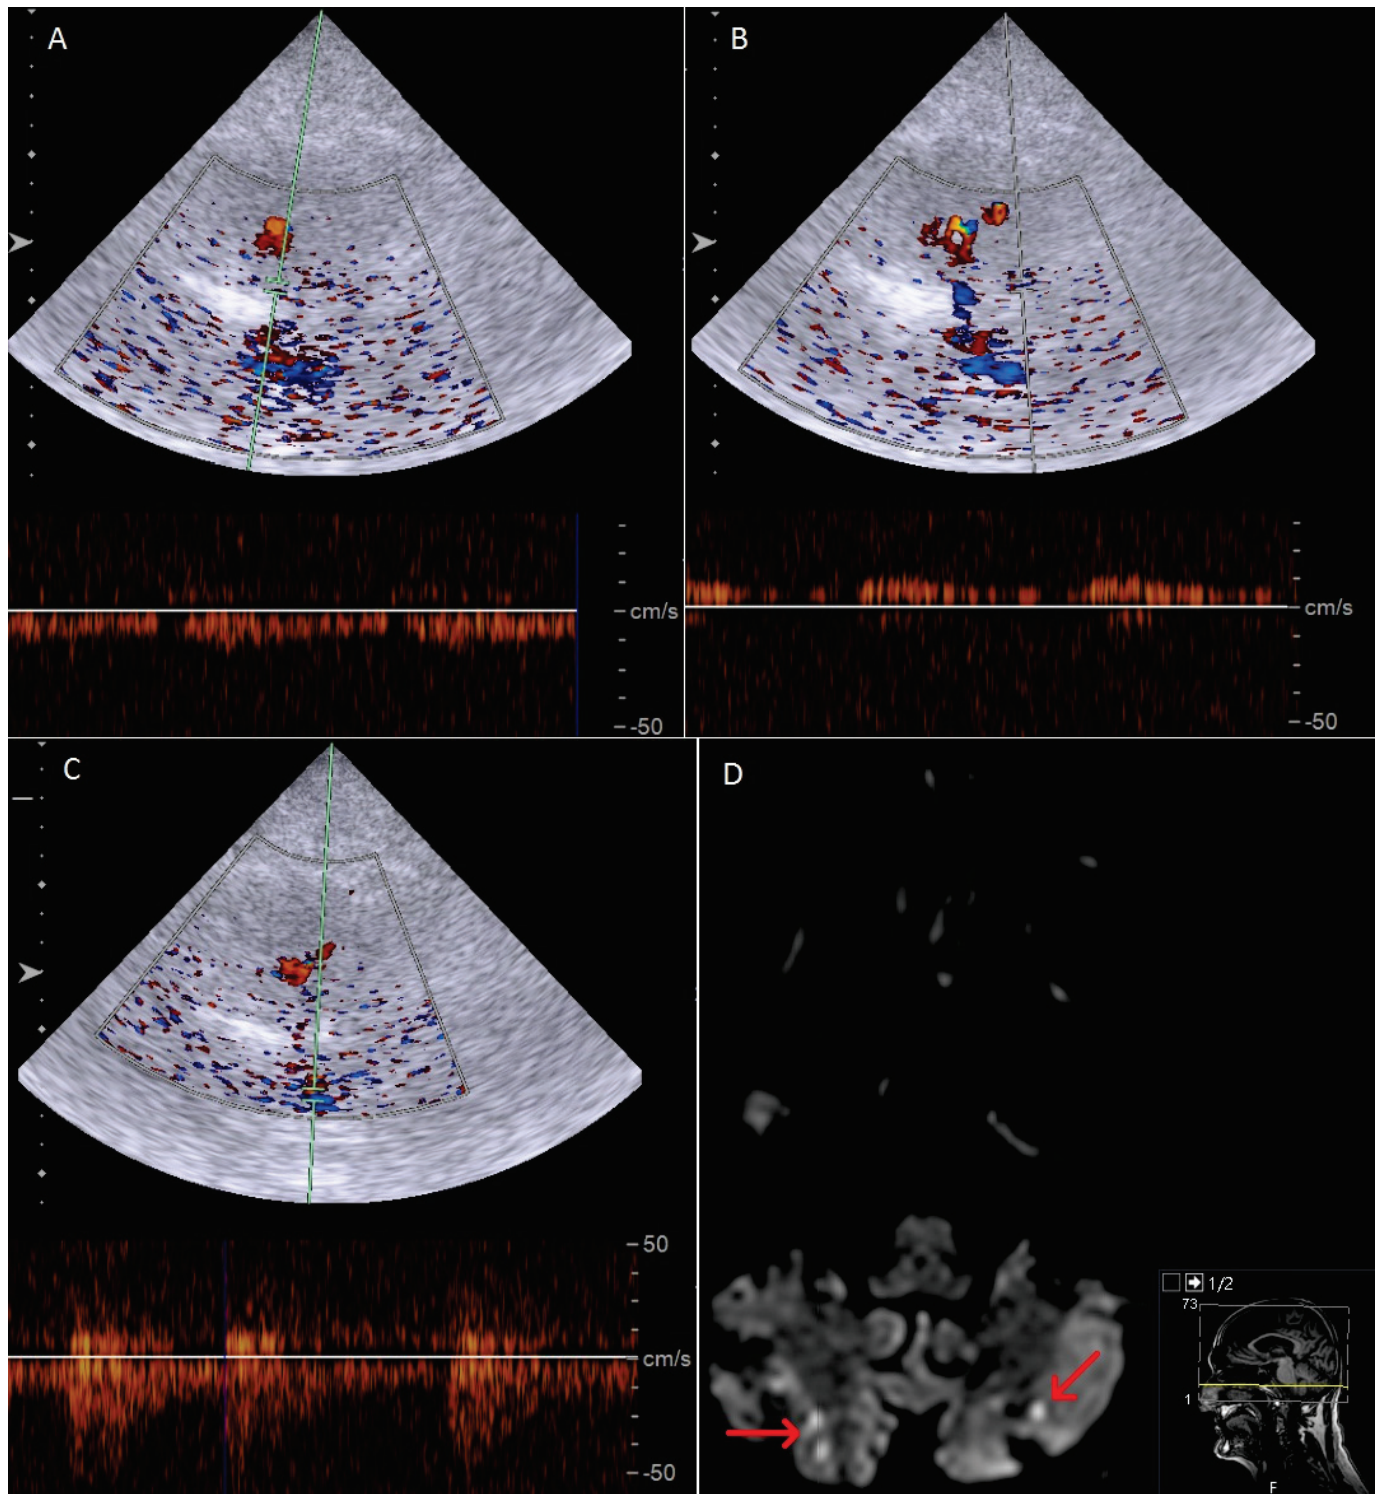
Exemplary case of a 72-year-old patient with GCA and images of a follow-up examination 4 months after the first diagnosis showing bilateral vertebral involvement. (A) Transcranial duplex sonography showing highly reduced pulsatility of the right distal VA. (B) Retrograde perfused left distal VA. (C) Decreased blood flow in the basilar artery. (D) MRI scan (Diffusion Weighted Imaging sequence) showing new bilateral cerebellar infarctions (red arrows).
